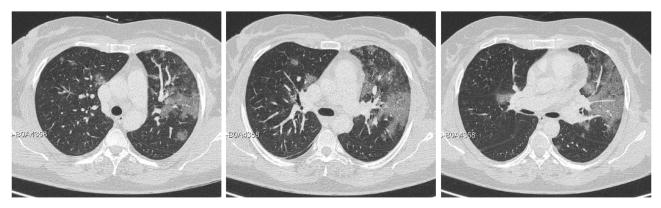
Lung CT scan 19 days after admission.
